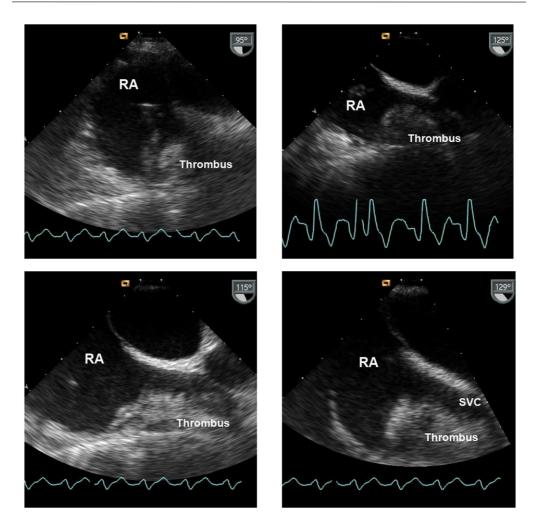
Pacemaker lead attached thrombus in a 78-year old male in transesophageal echocardiography. (RA = right atrium, SVC = superior vena cava)
